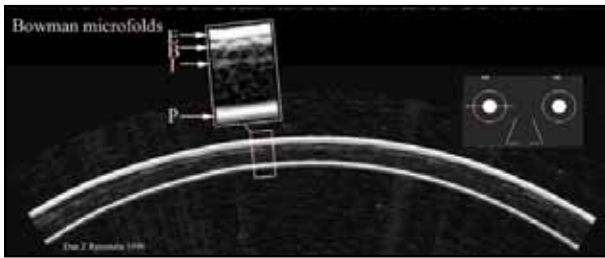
True Bowman's microfold. Horizontal VHF digital ultrasound corneal B-scan through the visual axis of a patient 6 months after LASIK. The surface of epithelium (E), Bowman's layer (B), the keratectomy interface (K), and the endothelium (P) are labeled. Inspection of the surface of Bowman's layer demonstrates a true microfold, with Bowman's layer showing a groove approximately 25 μm in depth and 100 μm in width.
